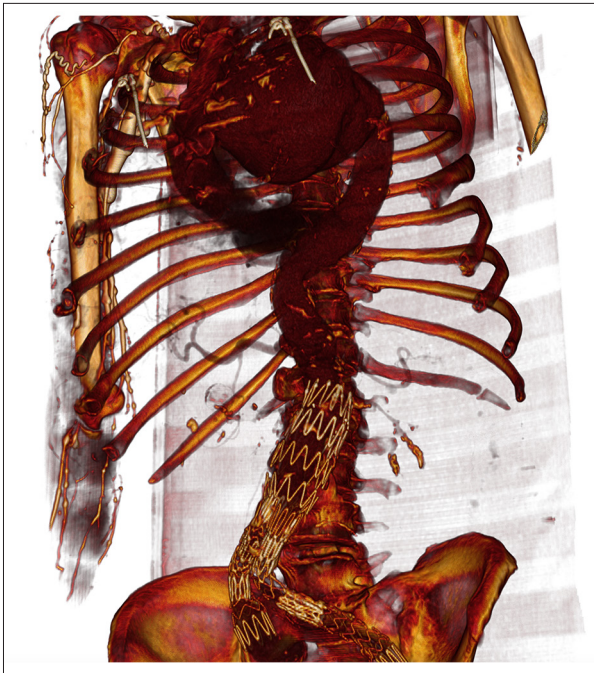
A 3-dimensional reconstruction of a CTA, including a giant arch and descending aneurysm and an abdominal stent graft previously implanted into the ruptured abdominal aortic aneurysm. CTA, computed tomography angiography.
